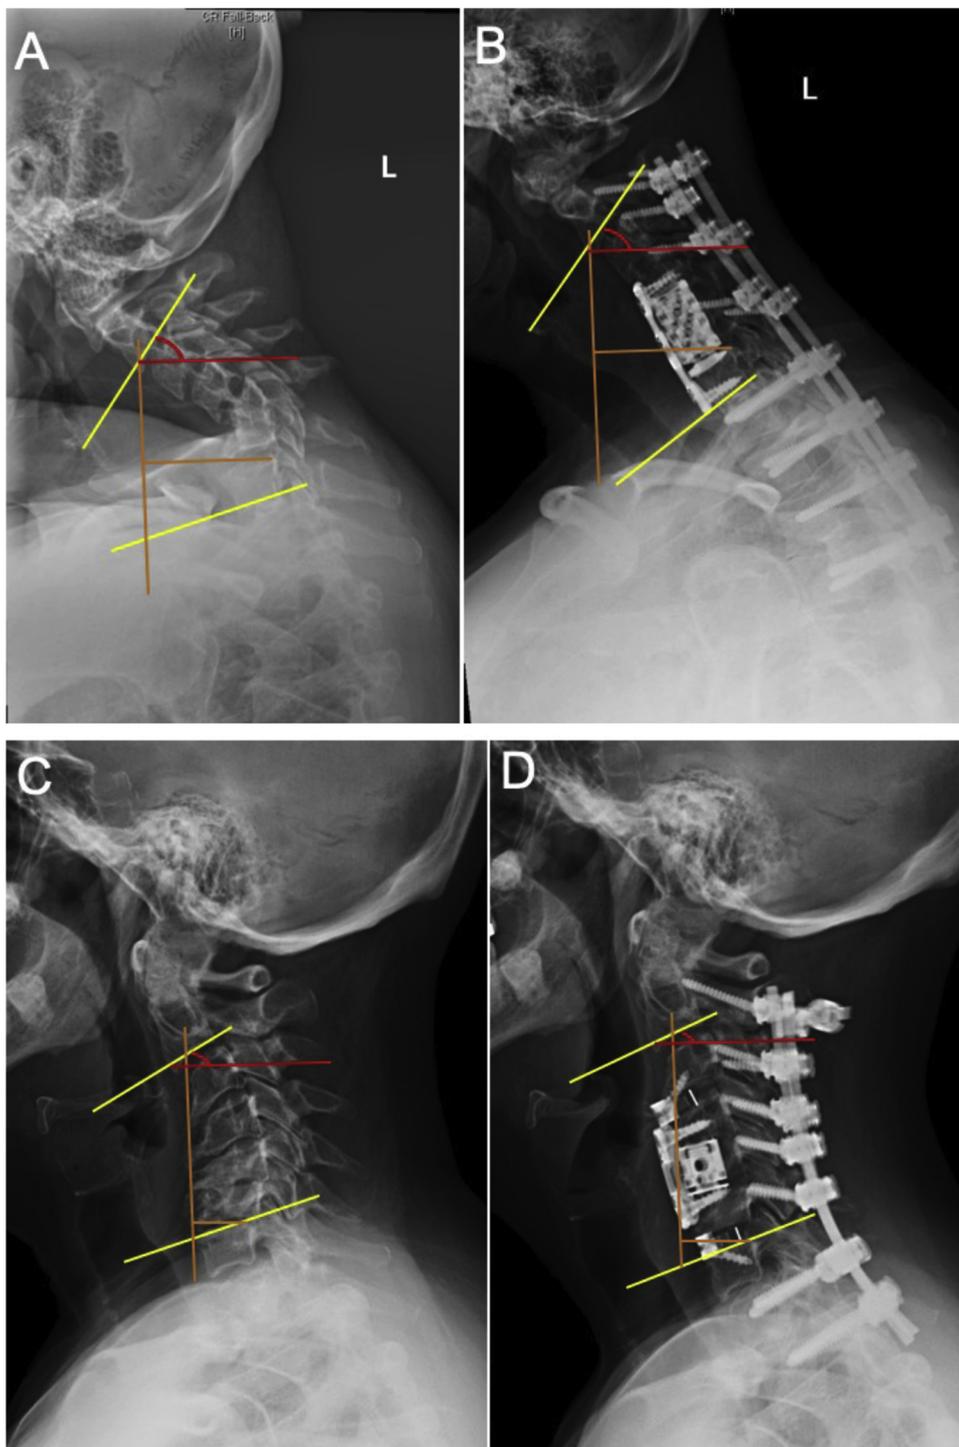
A) Pre- and B) post-operative lateral cervical spine X-rays following posterior approach arthrodesis with instrumentation.
